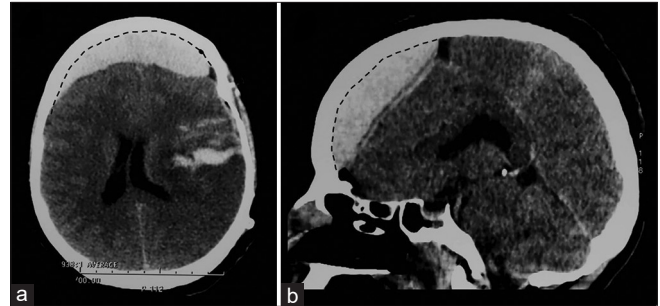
Postoperative head CT-scan done 4 h after the first surgery. Axial (a) and sagittal (b) images revealing a bifrontal acute epidural hematoma away from the initial left surgical approach.
